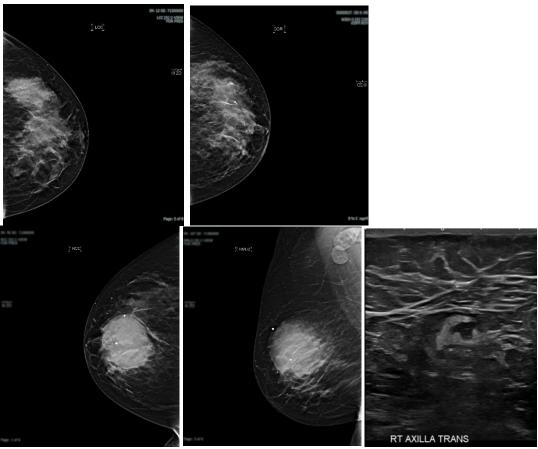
Imaging of breast lesions in patient with Cowden syndrome. Initial screening mammography from 2019 demonstrating multiple bilateral partially circumscribed, partially obscured masses (BI-RADS Category 0) in the (a) left and (b) right breasts. Follow-up diagnostic mammography in 2021 of the patient's new round mass 6.5cm with angular margins and complexity in the (c) CC view and (d) MLO view of the right breast. (e) Ultrasound of a right axilla lymph node demonstrating focal nodular cortical thickening at the same time.
